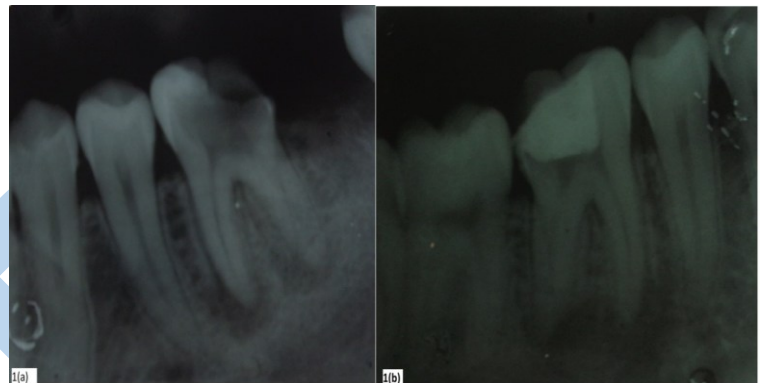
(a) & 1(b) showing Pre-op radiograph of Left mandibular first molar & Right mandibular first molar respectively.
